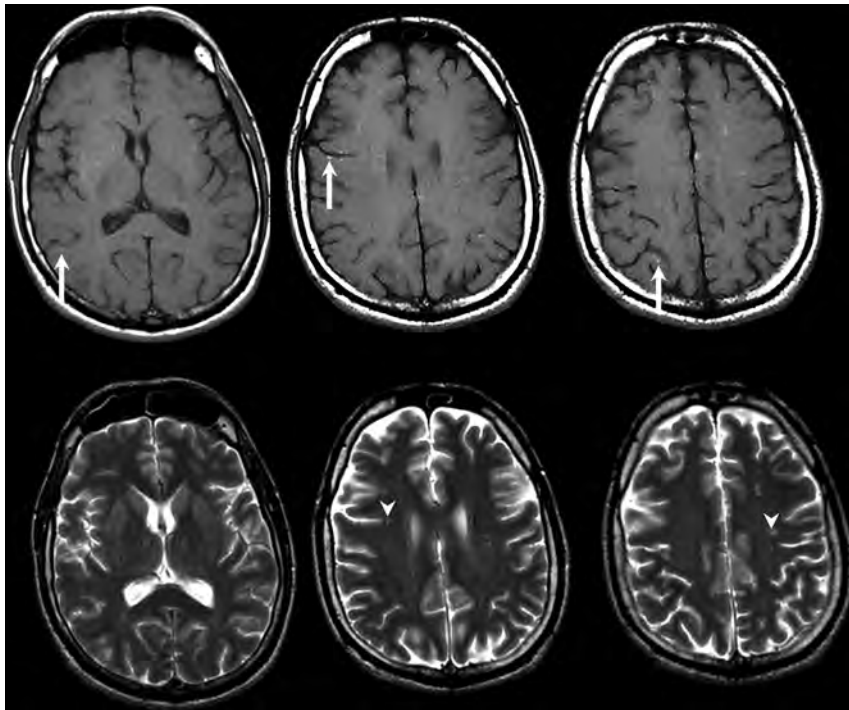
Patient with Nipah virus infection 1 month after infection. Selected axial T1-weighted images (upper row) show multifocal punctate high signal intensity on the cortical surfaces (arrows) as well as in the white matter. These did not enhance after contrast injection and disappeared on 6-month and subsequent follow-up MR imaging (not shown). Selected T2-weighted images (lower row) show noncorresponding multiple tiny focal increased signal intensity (arrowheads) in the white matter. These also became smaller or disappeared on follow-up MR imaging (not shown).
